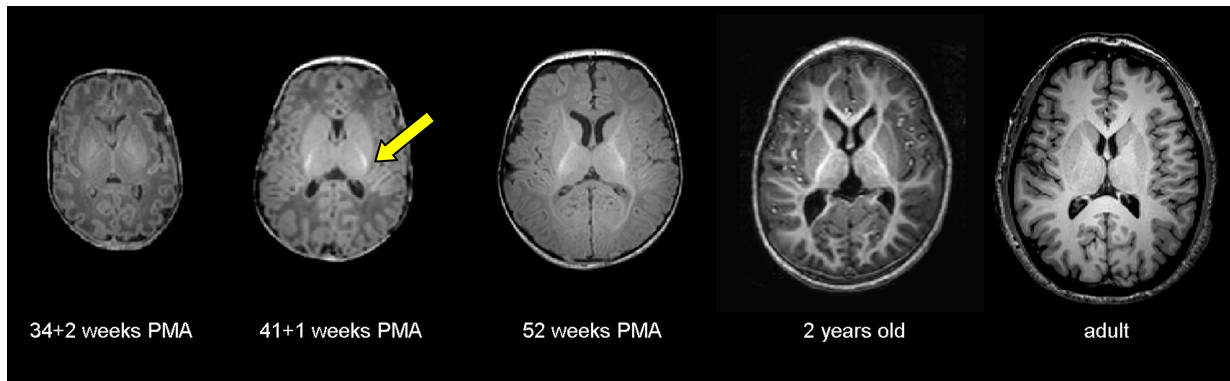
Progression of axonal myelination as visualised on T1-weighted MR imaging. At 34+2 weeks PMA, myelin is not evident and the white matter is uniformly of low signal on T1-weighted imaging. At approximately term equivalent age (41+1 weeks PMA), myelin is first seen in the posterior limb of the internal capsule (PLIC) as a thin band of high signal (arrowed yellow). By 3 months of age (52 weeks PMA), myelin is also now visible in the anterior limb of the internal capsule, and optic radiations. By 2 years of age, myelination is far more extensive and can be seen throughout the periventricular white matter and the external limb of the internal capsule. Therefore, in comparison to the preterm infant, the contrast of the white matter in the mature adult brain is completely reversed and universally of high signal. (*Images are not to scale*).
